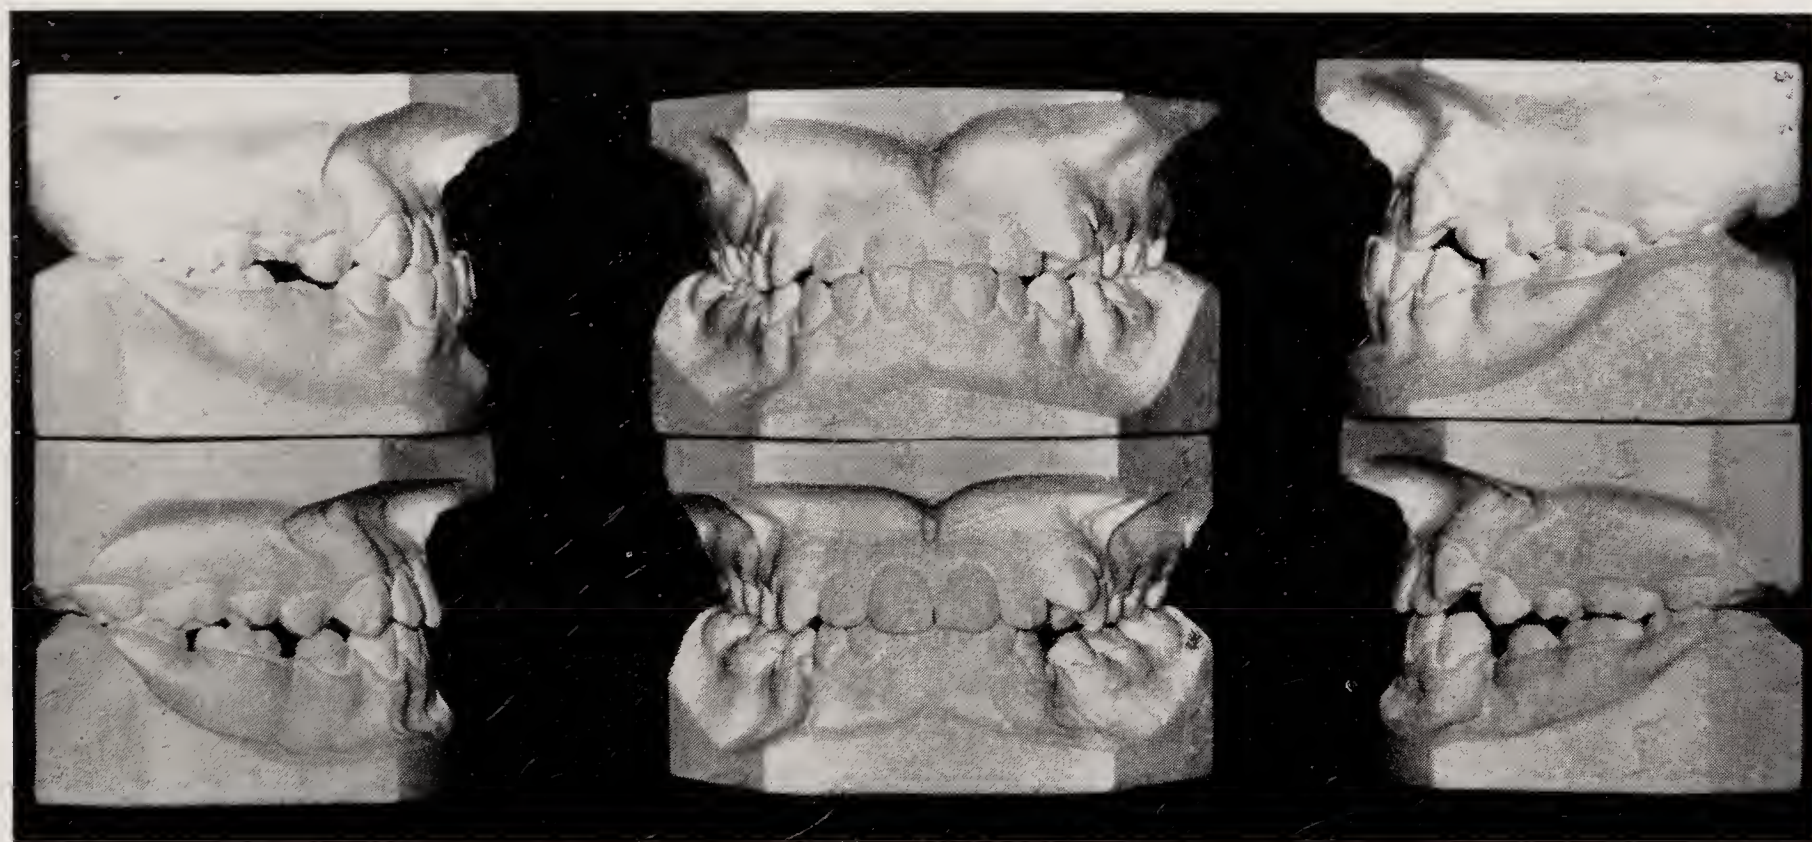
Models of case shown in Fig. 8 made on the same dates as the lateral skull X-rays were obtained from which tracings in Fig. 8 were taken. Although the position of the incisors has been improved aesthetically, their relationship is traumatic and the extraction of a tooth from the upper left buccal segment is probably contra-indicated for fear of losing the support of this buccal segment for the upper incisors which muscle pressures are attempting to position farther lingually.
